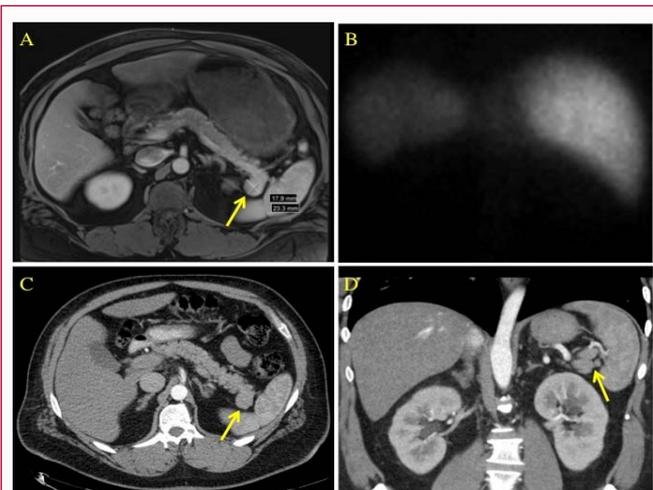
This is an axial slice from the MRI abdomen (VIBE fat saturated post-contrast) showing a 2.3 cm x 1.8 cm lesion in the pancreatic tail without pancreatic ductal dilation.
